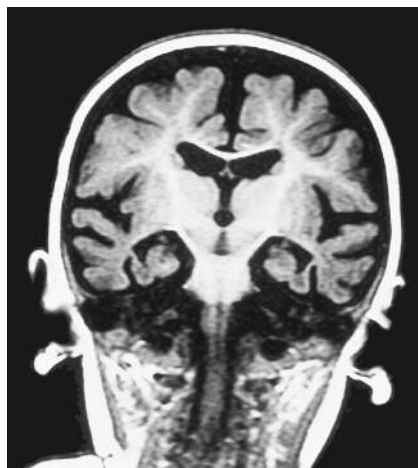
MRI showing lack of myelination and cerebral atrophy in a breastfed child whose vegan mother did not take vitamin B₁₂ supplements.
